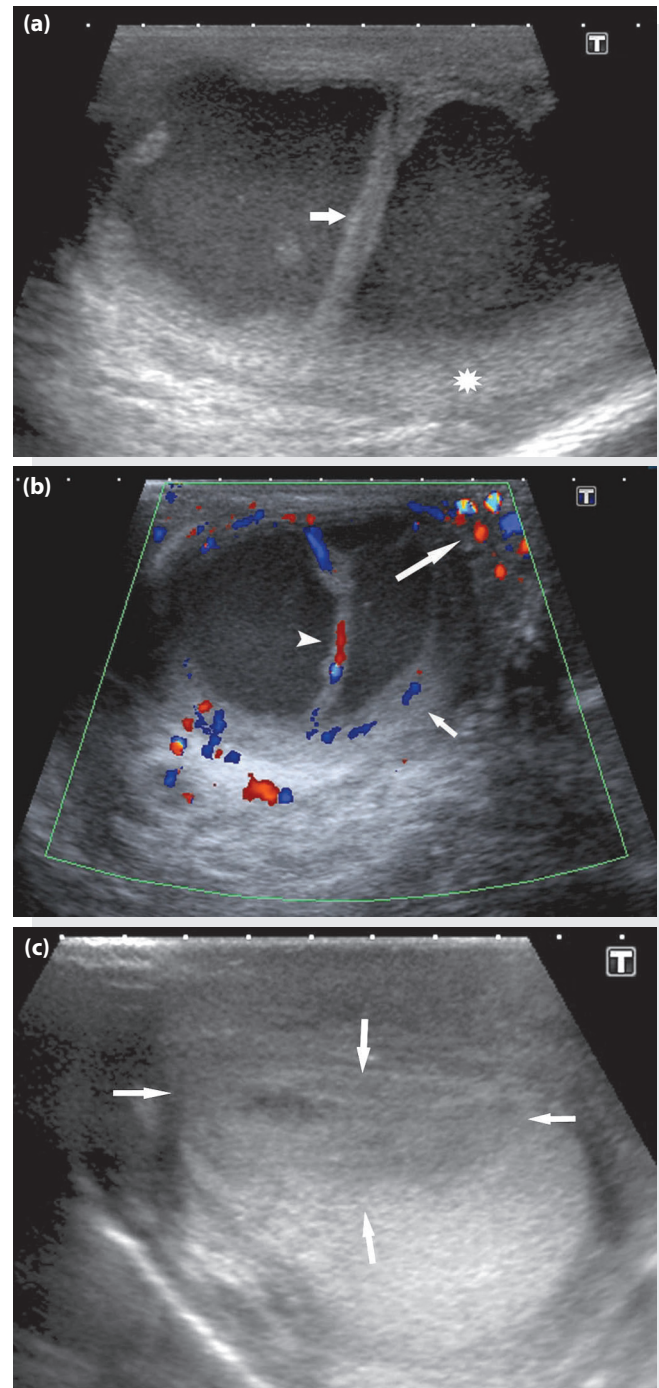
(a) Gray-scale sonography image demonstrates a large anechogenic cystic mass with a thick septum (arrow) and pressed testicular parenchyma (asterisk). (b) Color Doppler sonography image demonstrates the hypervascularity in the thick septum (arrow head), pressed testicular parenchyma (short arrow) and epididymis (long arrow) resembling orchid-epididymitis. (c) Gray-scale sonography image demonstrates heterogeneous hypoechoic area (arrows) at the right testis on follow up sonography after 2 months.
